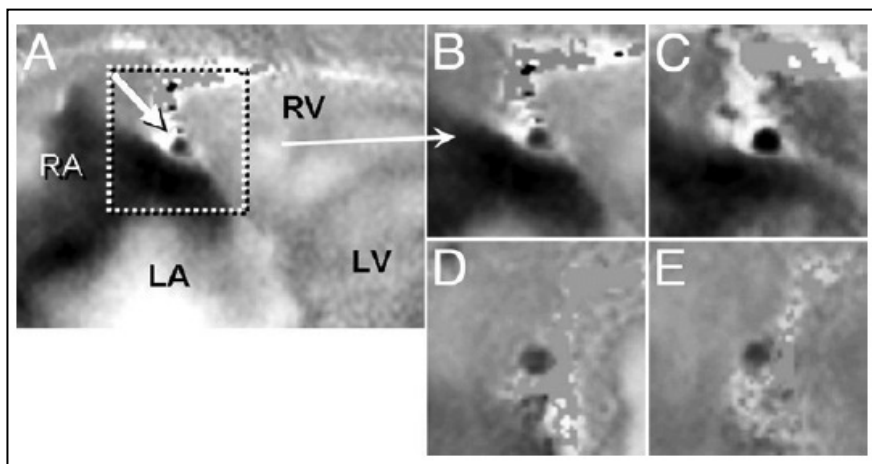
Flow Velocity-Encoded MRI Phase images. The black colour indicates the high velocity down through the image plane. Images B and C correspond to the flow in a healthy subject before and after isometric exercise, while images D and E show the flow before and after isometric exercise in a CAD patient. Image from reference [10]
